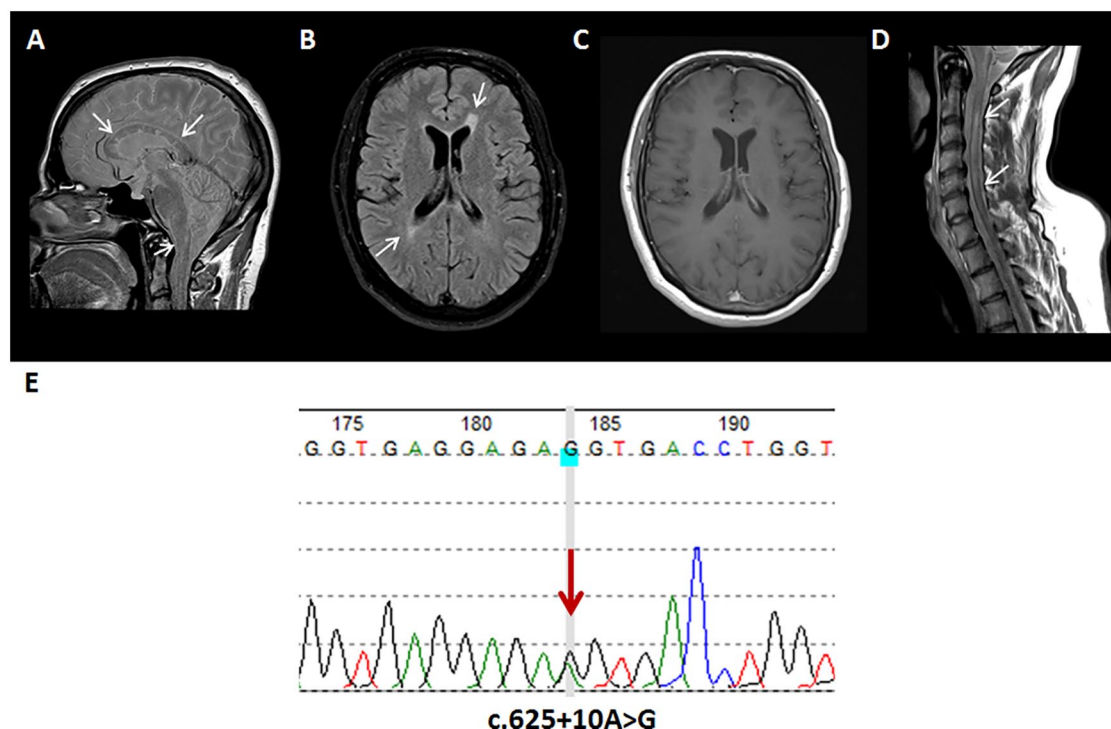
Magnetic resonance imaging (MRI) and sequence analysis of the TNFRSF1A gene in the patient with primary progressive multiple sclerosis upon adalimumab treatment. T2-weighted sagittal MRI (A) and fluid attenuated inversion recovery (FLAIR) axial image (B) of the brain showed periventricular, corpus callosum and brainstem localized T2-hyperintense lesions (white arrows). No gadolinium enhancement was observed in T1Gd-weighted axial images (C). Proton density (PD)-weighted sagittal MRI of the spinal cord (D) revealed hyperintense cervical lesions (white arrows). The DNA sequence chromatogram (E) demonstrates a heterozygous A>G nucleotide change (red arrow) in intron 6 of TNFRSF1A gene (c.625+10A>G, rs1800693).
